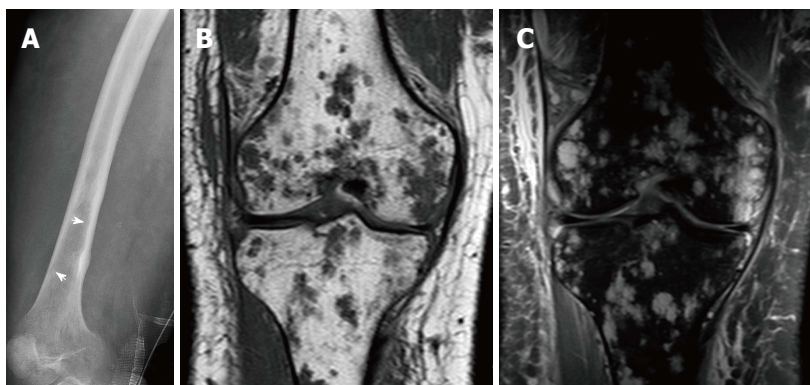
21-year-old man, who presented with pain and swelling of his leg. Radiograph of the femur demonstrates cortical erosion of the distal femur (arrows) (A). T1 weighted coronal magnetic resonance (MR) of the knee demonstrates innumerable focal lesions in the tibia and femur (B). These lesions are high signal intensity on T2 weighted coronal MR (C), however no contrast enhancement was seen within the lesions. Biopsy of the femur demonstrated a lymphatic microcystic lymphatic malformation.
